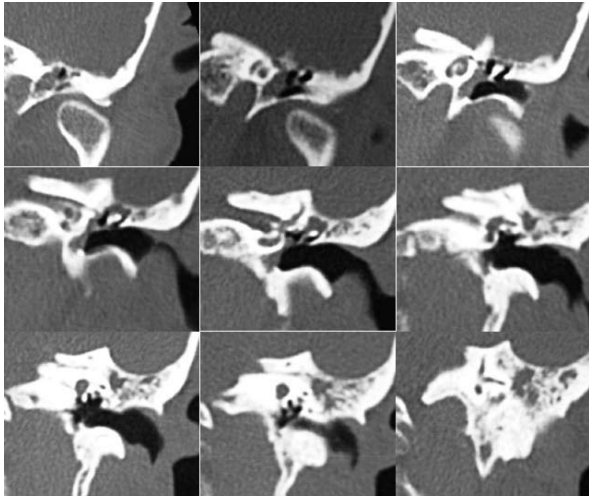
HRCT of left ear demonstrates how, the soft mass shadow occupying most of the middle ear, does not involve *tegmen tympani* and antri.
